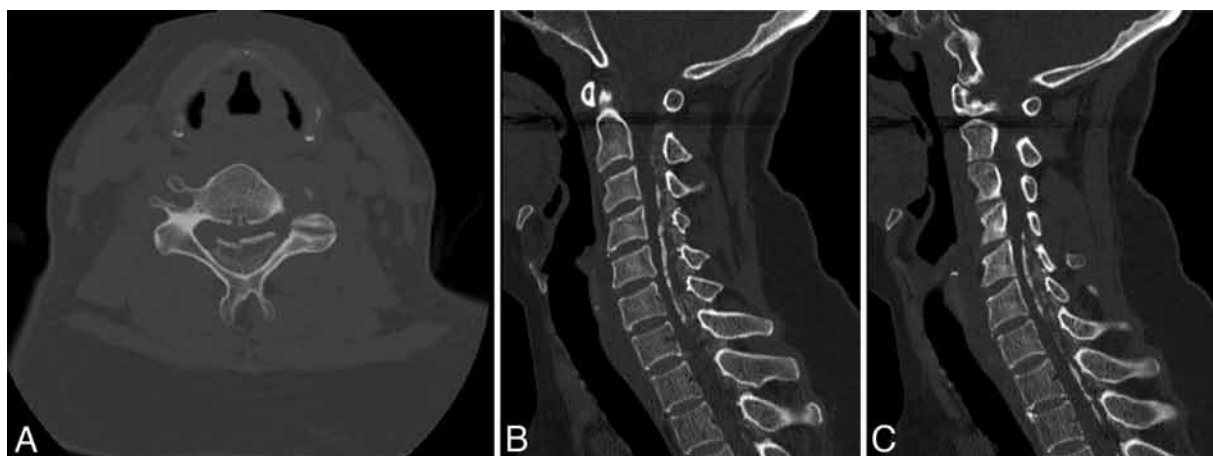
A: Axial CT scan at the level of the C-6 neural foramen demonstrating significant posteromedial compression, extending toward the left nerve root. B and C: Sagittal CT scans demonstrating the contiguous nature of the ossified ligamentum flava extending from C2–T3.
